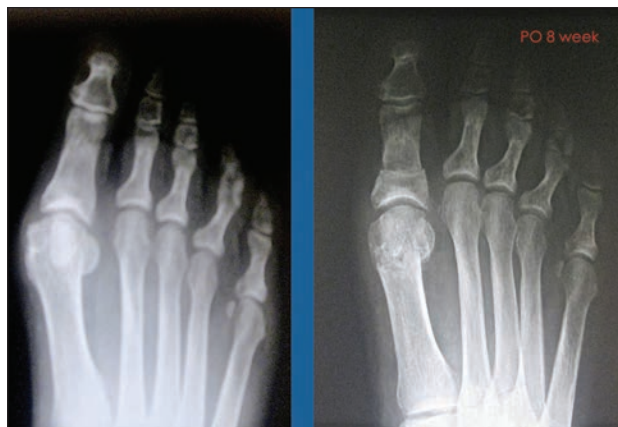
Pre-operative x-rays and post-op eight weeks x-rays following a Reverdin-Isham bunionectomy.
